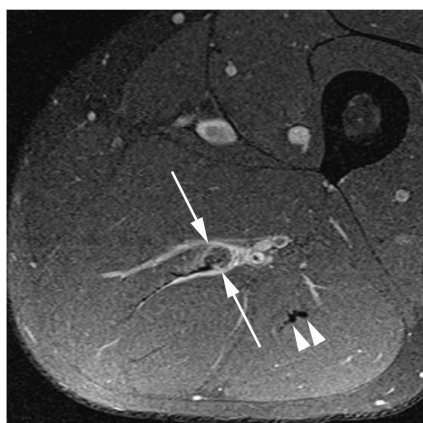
Axial PDw FS MRI showing oedema surrounding the proximal myotendinous junction of the semimembranosus muscle, with a thickened adjacent tendon exhibiting signal changes involving more than 50% of its area (arrows). In the British Athletics muscle injury classification, this is considered as a grade 3c injury. There is no fiber disruption present. Using the Chan classification, this injury was scored as grade 1 regarding its severity. Using the modified Peetrans grading system, injury was scored as grade 1.
